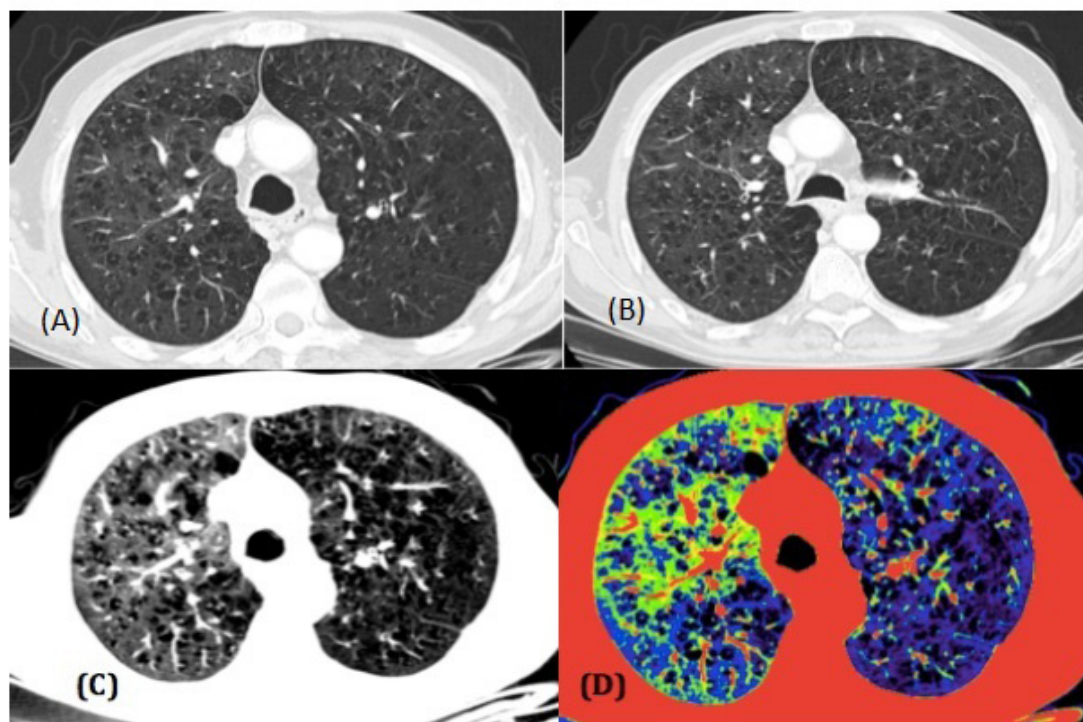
A 52-year-old male, heavy smoker presenting with cough and dyspnea. (A) & (B) Axial inspiratory and expiratory CT images show upper lobar centrilobular emphysema (yellow arrow = central dot sign) and diffuse large area of low attenuation, no clear difference between inspiratory and expiratory images could be appreciated. (C) Corresponding inspiratory axial CT image in narrow window accentuates the contrast difference between the normal lung and low attenuation regions. (D) Combined color-coded narrow window inspiratory CT image identifying the air trapping areas (blue areas) and shows the normal lung (green areas) & clearly distinguishing the emphysematous areas (black areas).
